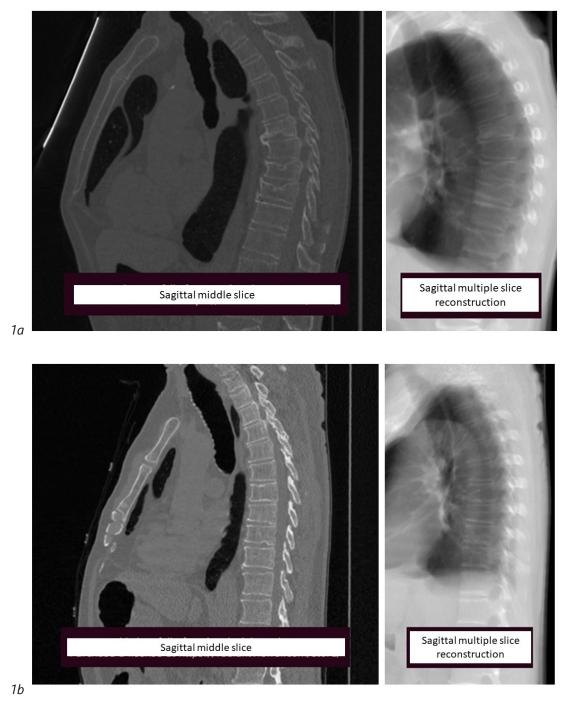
Examples of the superposed sagittal reconstructions at the right, with the referral sagittal middle reconstruction (slice) from the CT scan
